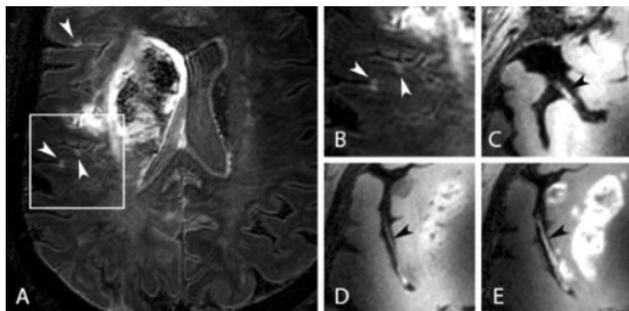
A 75-year-old female patient presented with ischemic stroke of the right MCA territory. (A) Transverse 7T T2-weighted FLAIR image shows and infarct of the right MCA territory with three CMIs (white arrowheads); (B) shows a zoomed view of the box drawn in A. (C–E) Transverse 7T T2-weighted intracranial vessel wall images before (C and D) and after
